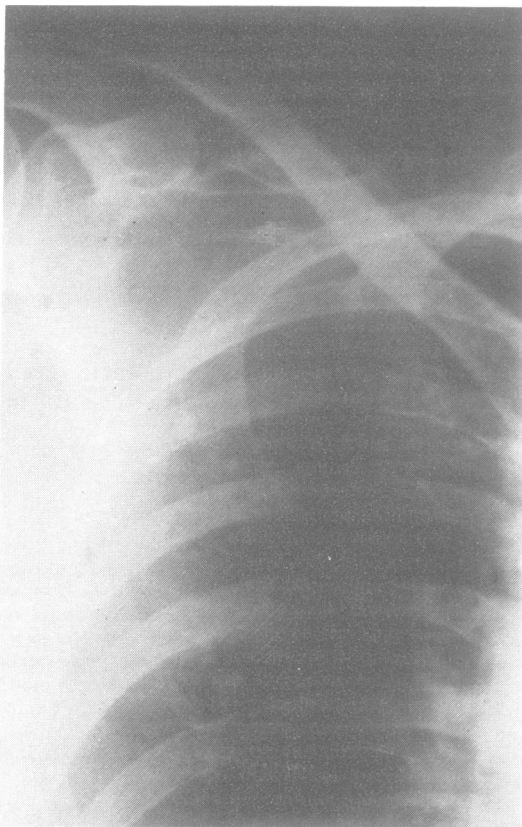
Radiograph of right upper thorax showing osteosclerotic lesions.
